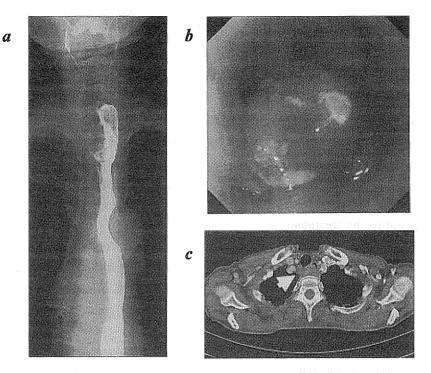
Radiologic and endoscopic findings for the tumor at the initial diagnosis. Panel a, Esophagography: A filling defect, measuring 30 mm in size on the upper esophagus is visualized. Panel b, Endoscopy: An elevated tumor was found at the cervical esophagus just distal from the esophageal oriphis. Panel c, Chest CT: Both the thickness of the cervical esophageal wall and swelling of cervical paraesophageal node are visualized.
